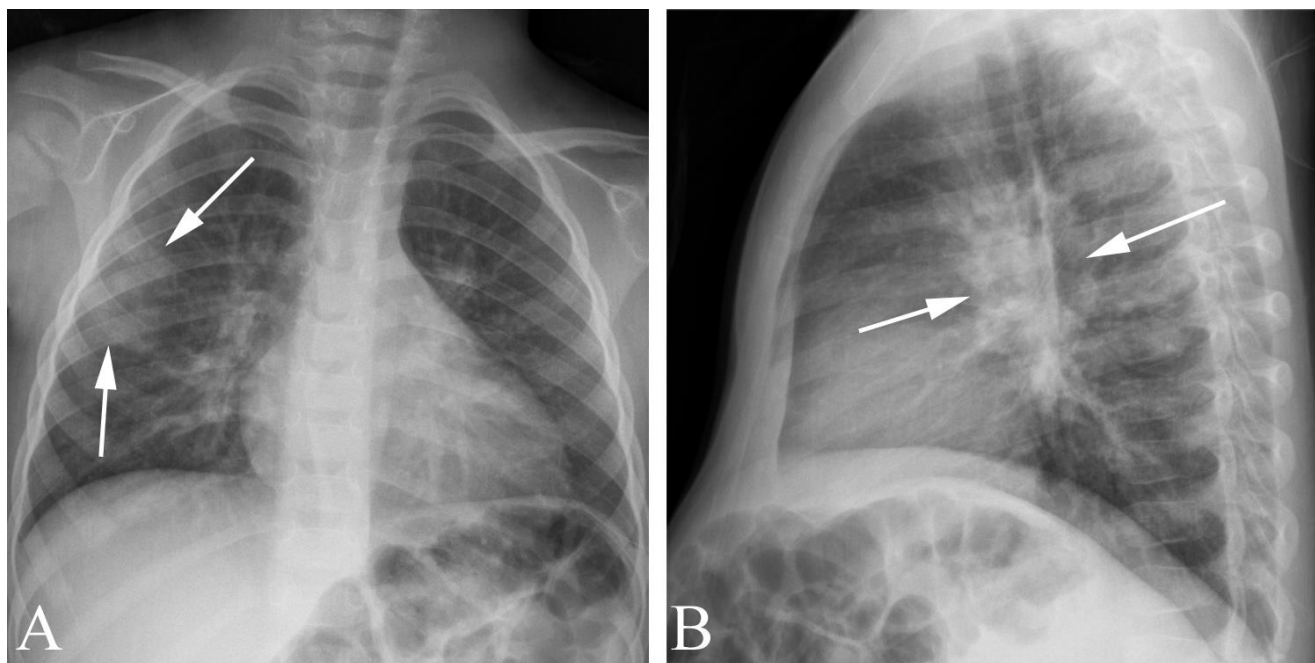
Mixed pattern in a 3 year old with fever, cough, and dyspnea. A. Frontal chest radiograph shows both prominent hila, streaky densities radiating from the hila, and abnormal opacity in the right mid-lung (arrows), only part of which may be accounted for by an overlying scapular shadow. B. Lateral exam confirms prominent hila (arrows). In such cases, it is difficult to tell if the vague pulmonary opacity represents atelectasis (which may accompany viral and/or atypical pneumonia) or a superimposed bacterial infection
